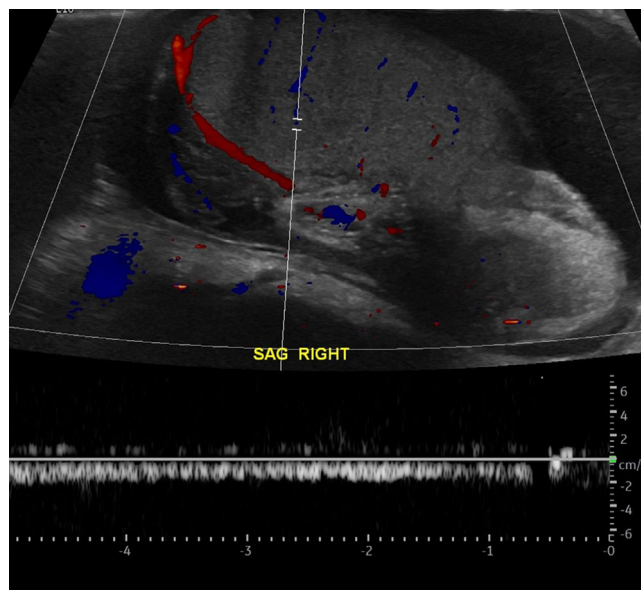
A 42-year-old male presents with acute right scrotal pain. Grayscale (A) and color flow Doppler (B) ultrasound images demonstrate the whirlpool sign, compatible with twisting of the spermatic cord. Testicular torsion was confirmed intraoperatively
